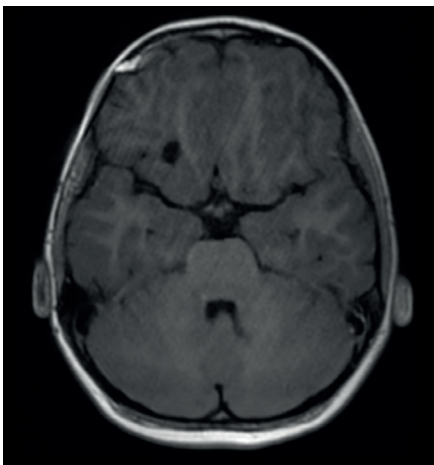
Third-year followed up T1-weighted contrast of MRI of the brain (axial) shows no sign of remnant of tumor
